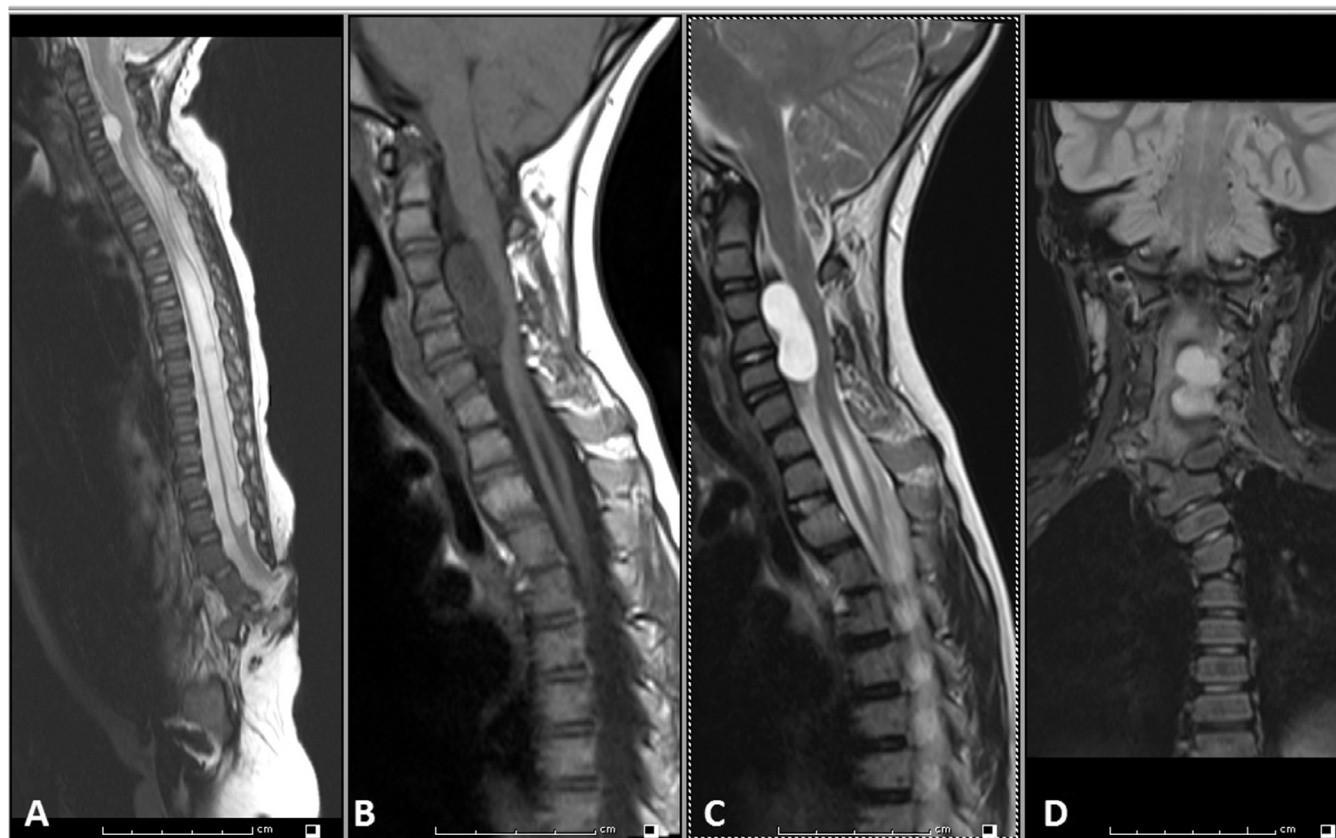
MRI of the whole spine at 4 months of age: (A) sagittal T2 sequence demonstrating the cervical neurenteric cyst, a holocord syrinx, and a tethered cord. Follow-up MRI at 7 years of age: (B) sagittal images showing the cystic lesion to be hypointense on T1-weighted sequences, and (C) hyperintense on T2-weighted sequences. (D) Scoliosis of the lower cervical spine noted on coronal sequence.
